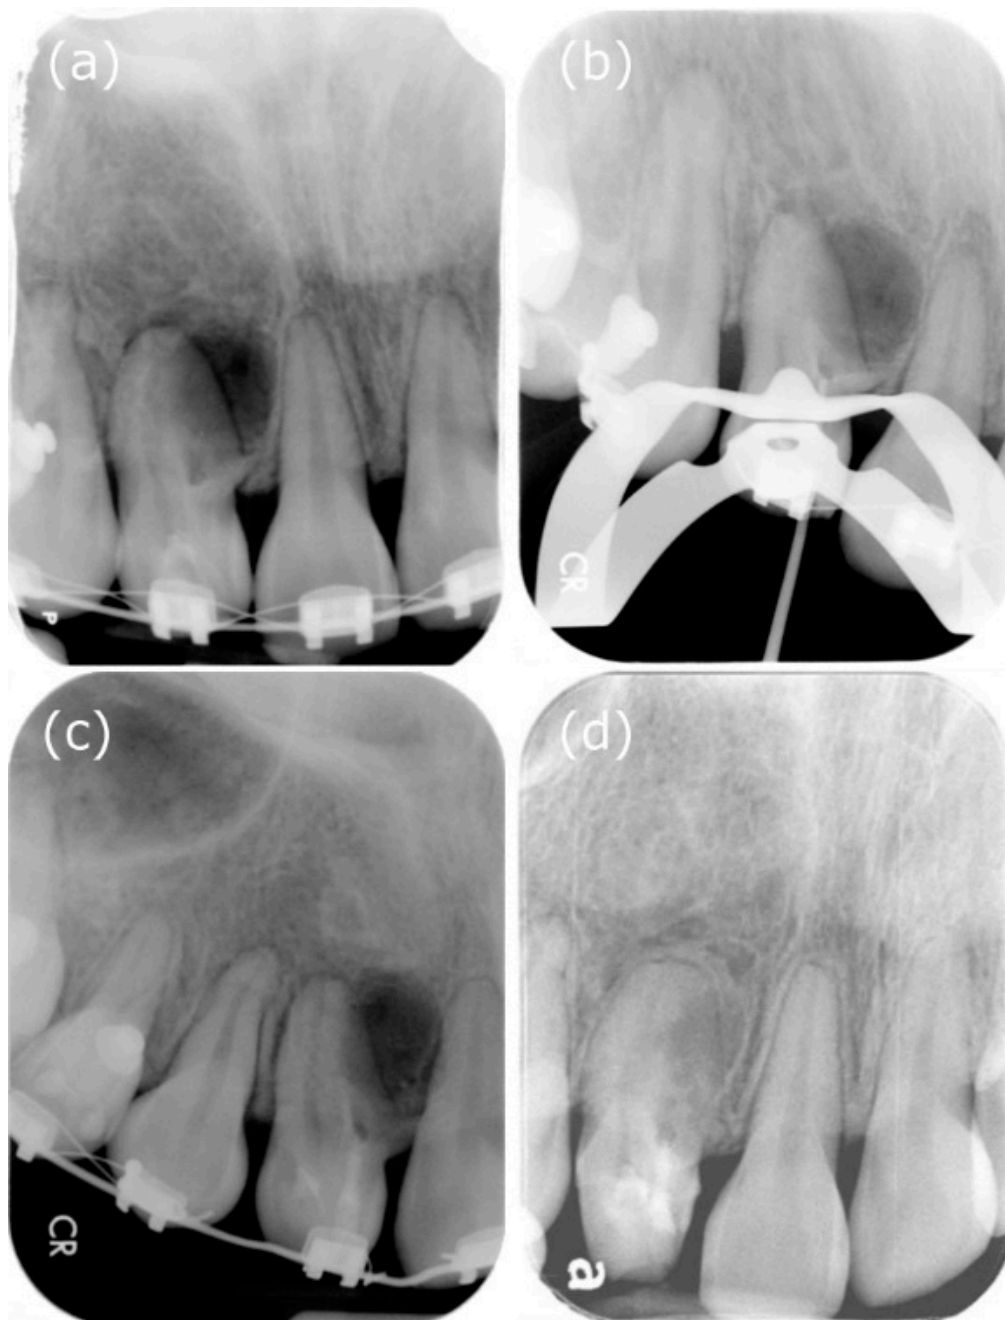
Periapical films during the treatment procedure. (a) X-ray showed that the radiolucent invagination looks like a tooth inside another. Additionally, there was dentin invagination lined by enamel into the main canal space, spreading into the mesial part of the middle root. Tooth 12 appeared to be associated with a large peri-invagination radiolucent lesion around the opening of the invagination near CDJ. (b) Measurement of the working length. (c) Mineral trioxide aggregate was used to seal the invagination. (d) Follow-up at two postoperative years. The patient complained of no clinical symptoms, and the peri-invagination lesion had healed significantly.
